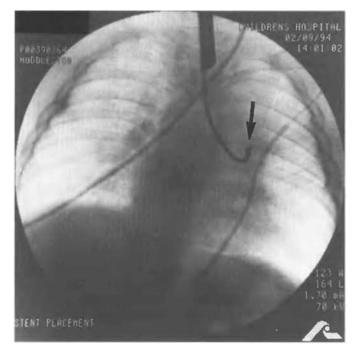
This chest radiograph was taken during fluoroscopy following completion of stent placement in the left mainstem bronchus of a child. To confirm that the upper lobe orifice is patent distal to the stent a small flexible bronchoscope is inserted into the orifice (arrow)
